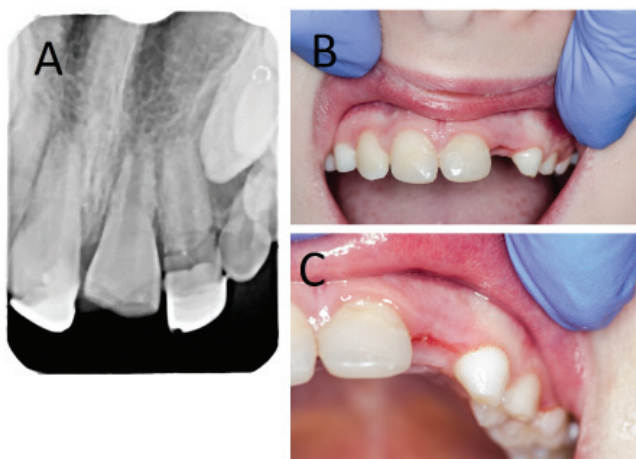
A – radiograph taken at the day of trauma – crown root fracture of the upper left lateral incisor (#22). B, C – up-front view of traumatized area after 2 weeks of healing and suture removal
